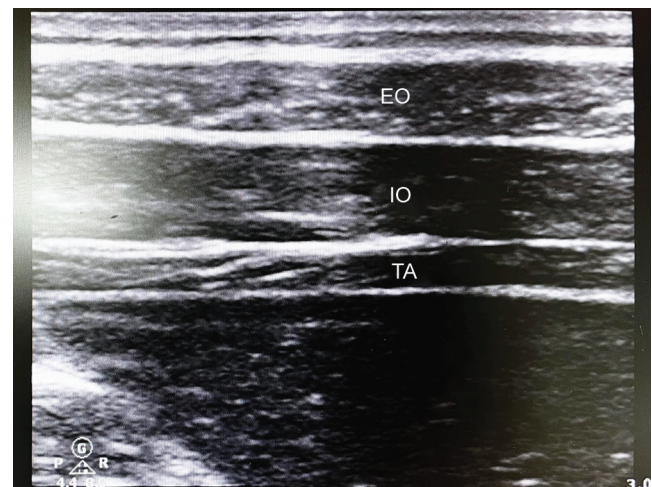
Ultrasound image in a patient depicting the thickness of the external oblique (EO), internal oblique (IO), and the transversus abdominis (TA) muscle
